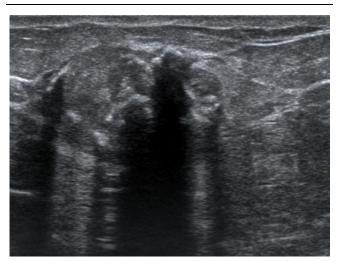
Ultrasound of the right breast showing a well-encapsulated hypoechoic heterogeneous mass due to calcifications in the retro-areolar area.
